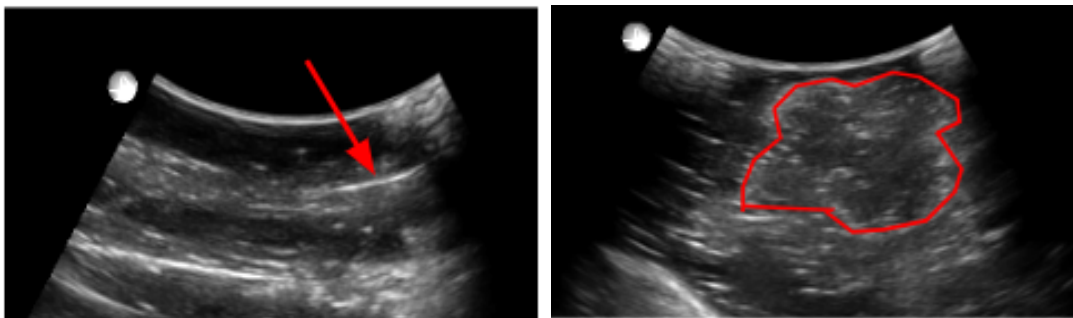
Ultrasound images of the second prototype. (left) ultrasound image showing needle on upper right corner bright line. (right) ultrasound image showing tumor embedded in the cervix.
